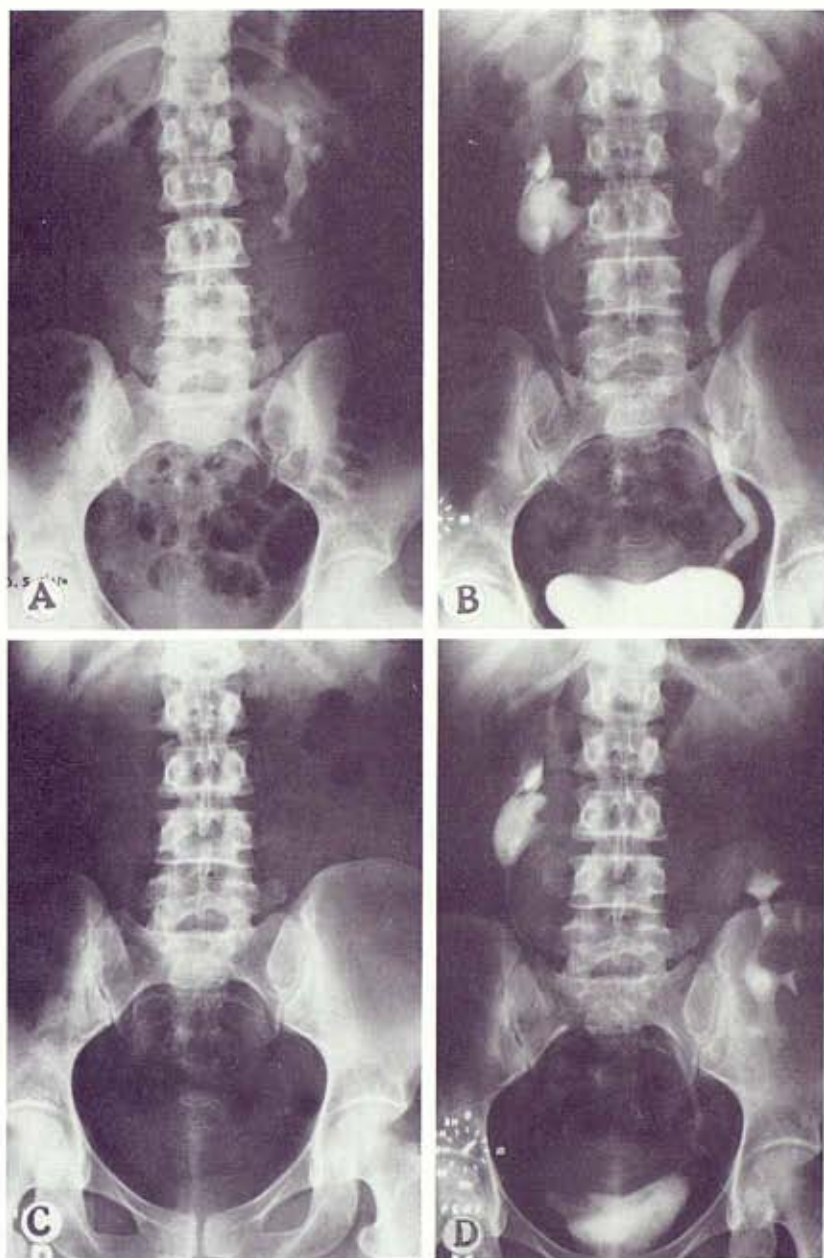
Case 9. *A*, x-ray shows staghorn calculus in horseshoe kidney. *B*, preoperative x-ray. *C*, postoperative x-ray shows complete removal of calculus. *D*, postoperative IVP.
